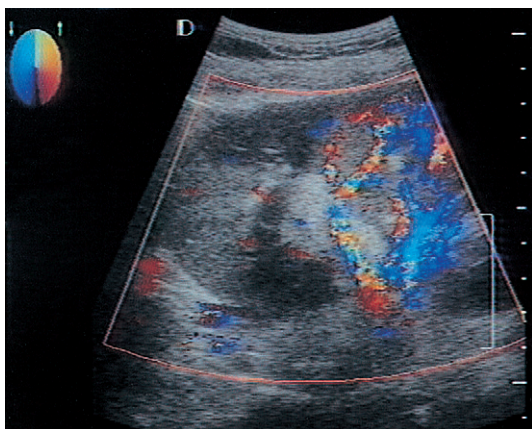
Colour flow Doppler image demonstrating blood flow at the hilum and within the kidney. Note there is absent flow to the upper pole in this patient with focal pyelonephritis.
